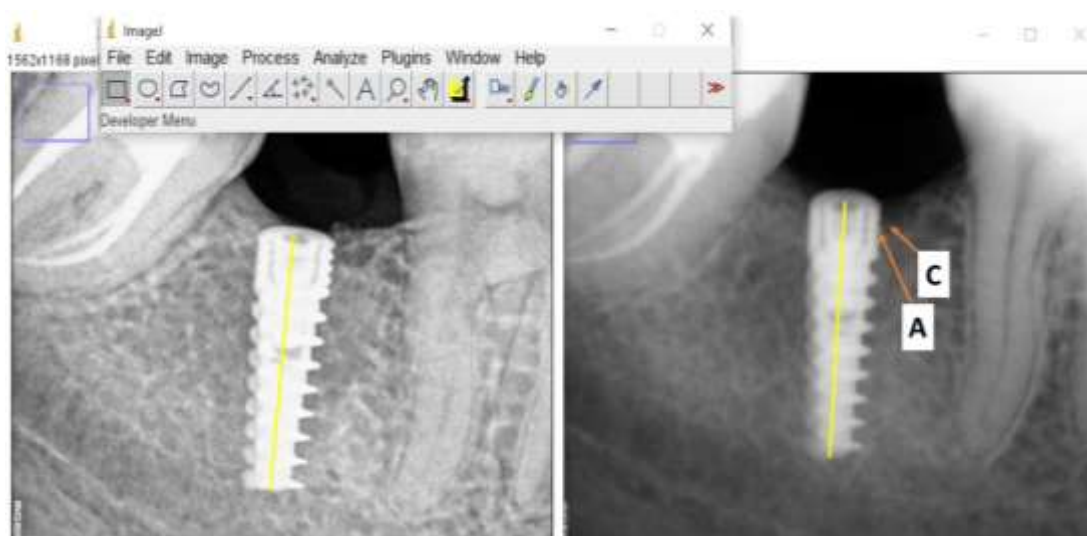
Radiographic image analysis using Image J software. 'A'- Apical-most point of crestal bone level 'C' – Coronal-most point of crestal bone level; both in relation to first thread of implant body. Yellow line- Length of implant used for calibration of image prior to measurements.
